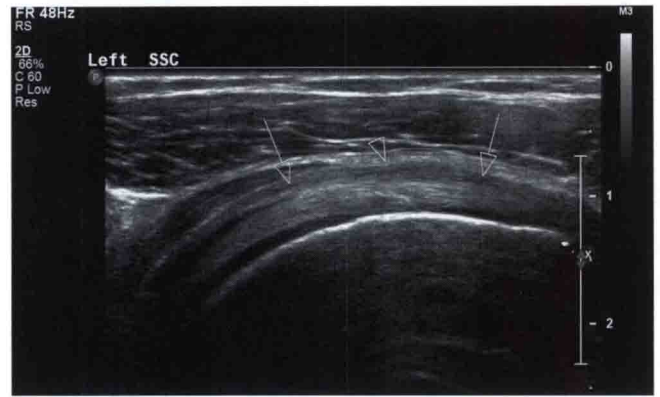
Normal subscapularis tendon on transverse ultrasound view. (A) The probe is positioned medial to the bicipital groove for an axial scan. Note the abduction of the patient's forearm. (B) The tendon has
